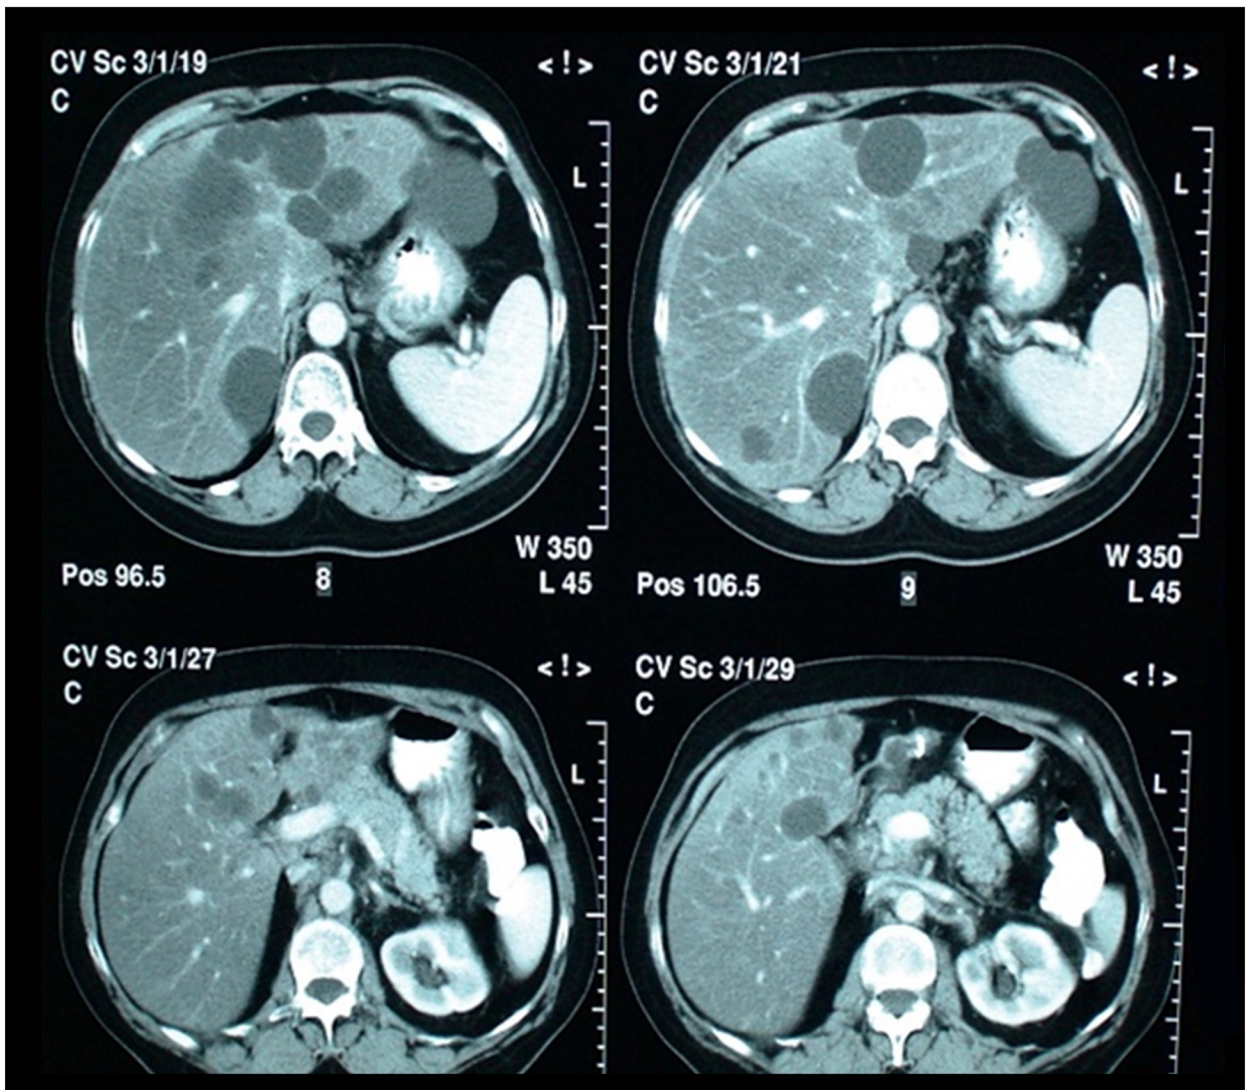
Abdominal-pelvic computed tomography scan with oral and intravenous contrast showing multiple liver cysts.
